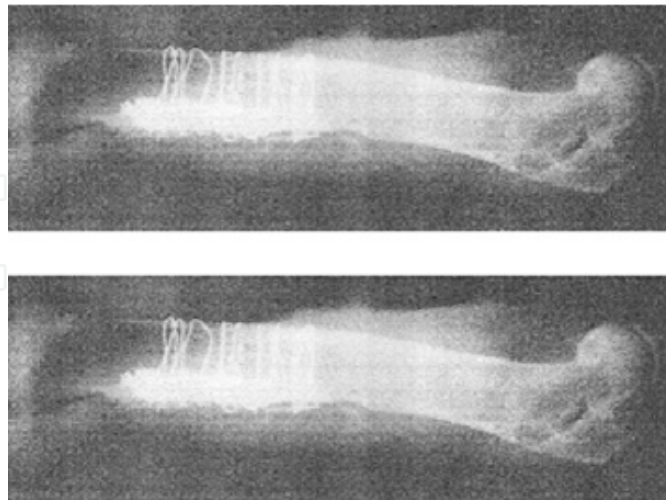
The X-ray of implants wired to the bone
